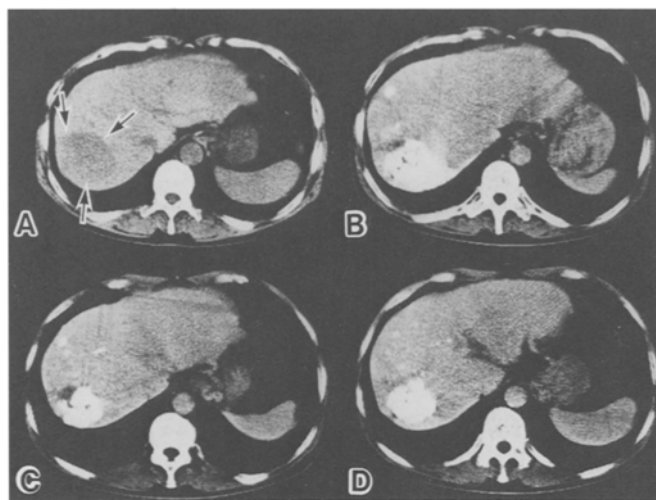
Computed tomogram of case 24. A [before TAE] A low-density space-occupying lesion (SOL) is seen in S7 of the liver (arrow). Its size is 65×52 mm. B, C, D [2 weeks (B), 6 weeks after TAE (C, D)] Lipiodol retention is visible in the SOL. The size and rate of Lipiodol retention is 52×48 mm (B), 48×38 mm (D), 90% (B), and 85% (C, D), respectively. We calculated the TR to be 43.4% and the TN, 90% in this case
